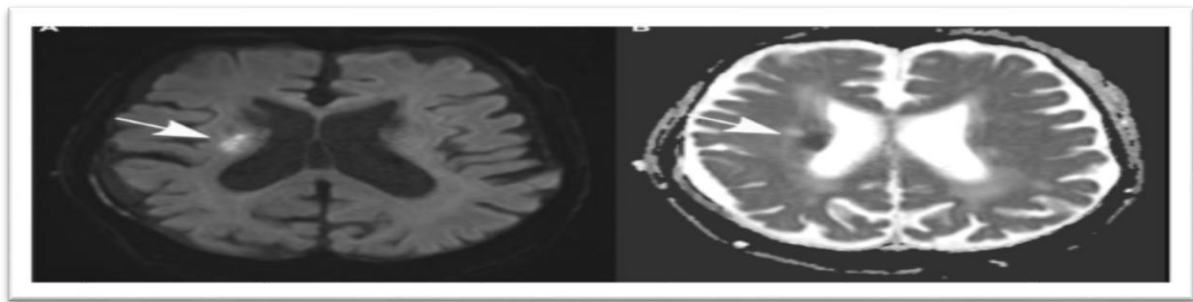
MRI images (A) showing an elevation in signal (B) decrease in right corona radiata
